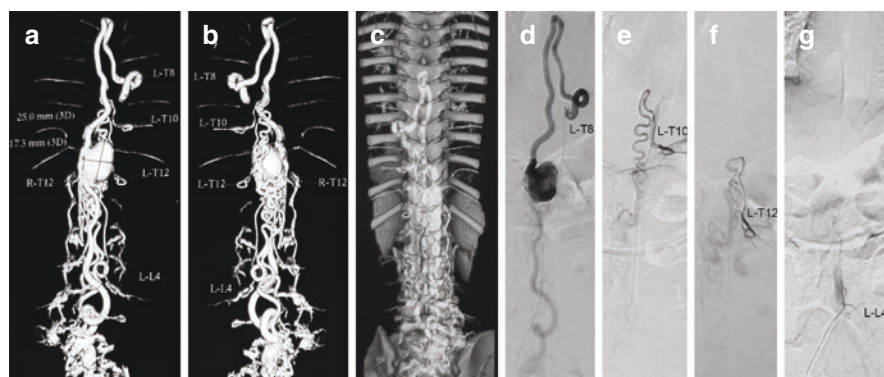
A case of pediatric perimedullary arteriovenous fistula (3-year-old boy). (a–c) Lesion structure shown by CTA is consistent with (d–g) the result of superselective DSA in terms of feeding arteries, location of fistula, and the diameter of venous pouch
